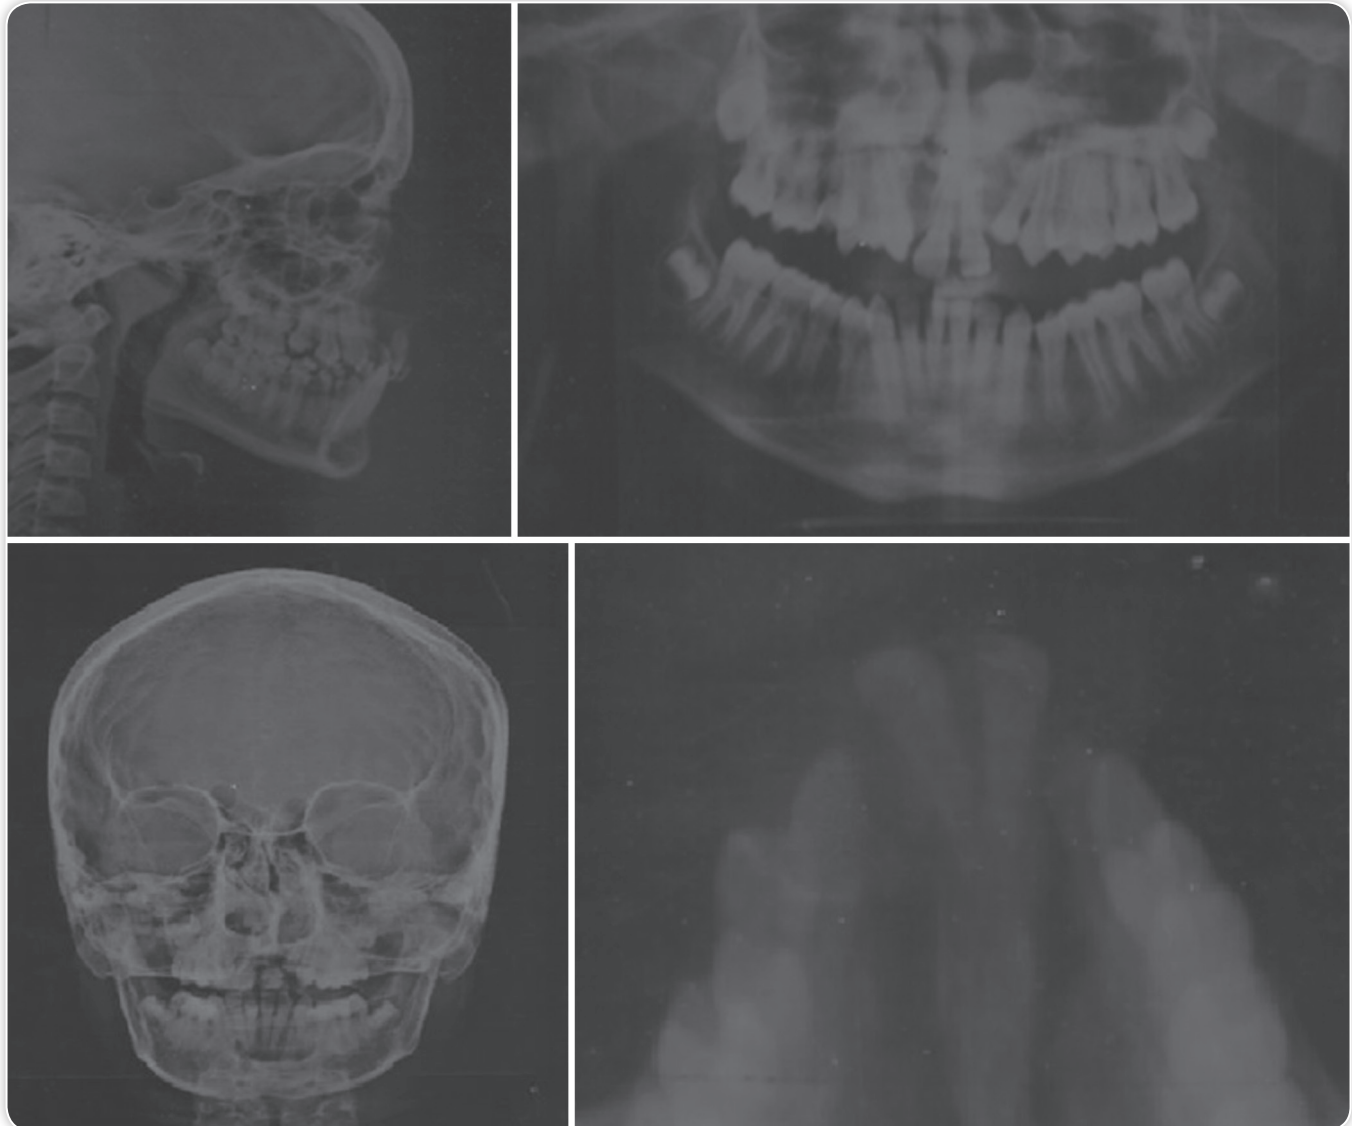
Pre-treatment radiographs of case 1
